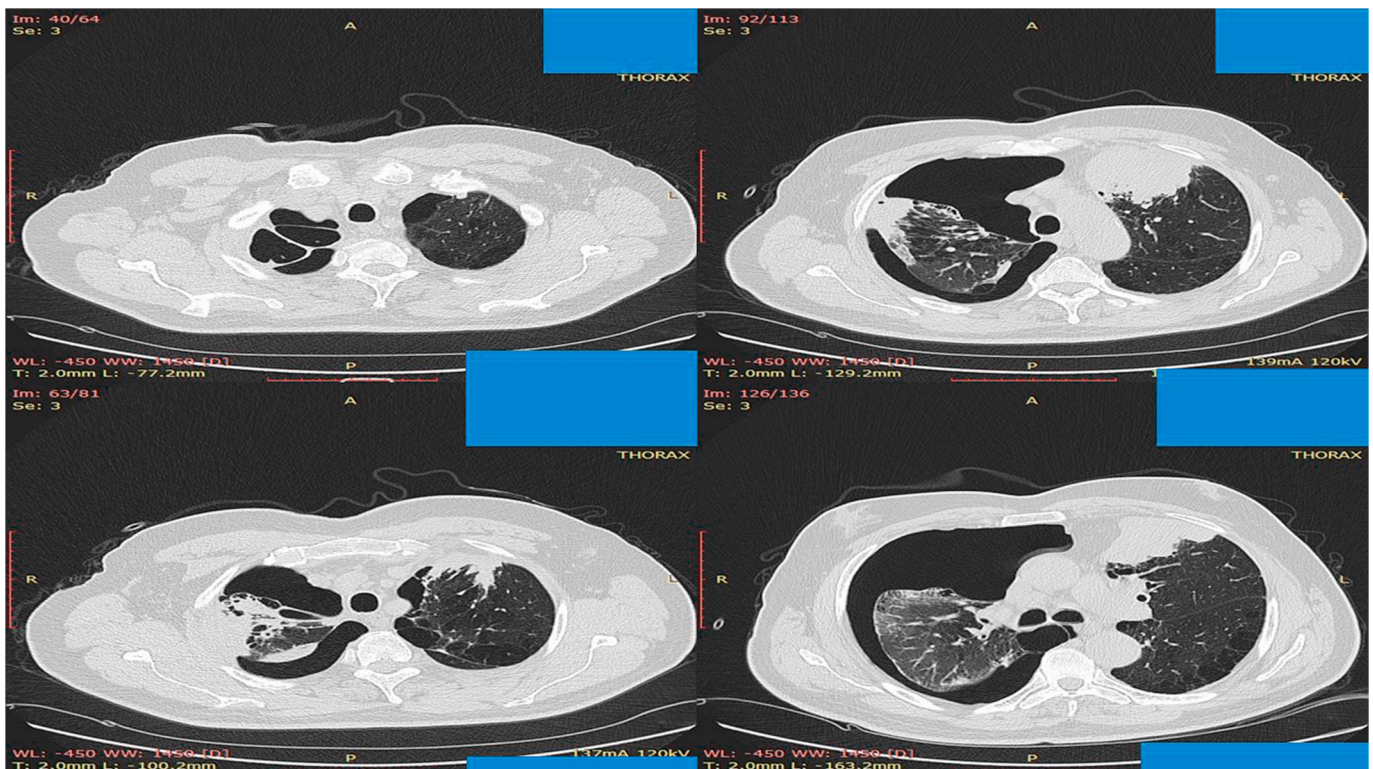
CT of the thorax with pneumothorax.
